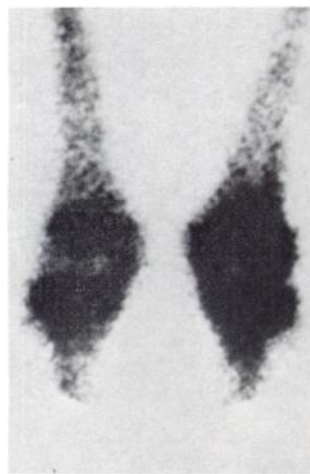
Bone scintigram of both knees obtained from Patient 1. There is asymmetry and increased cortical and metaphyseal uptake.
